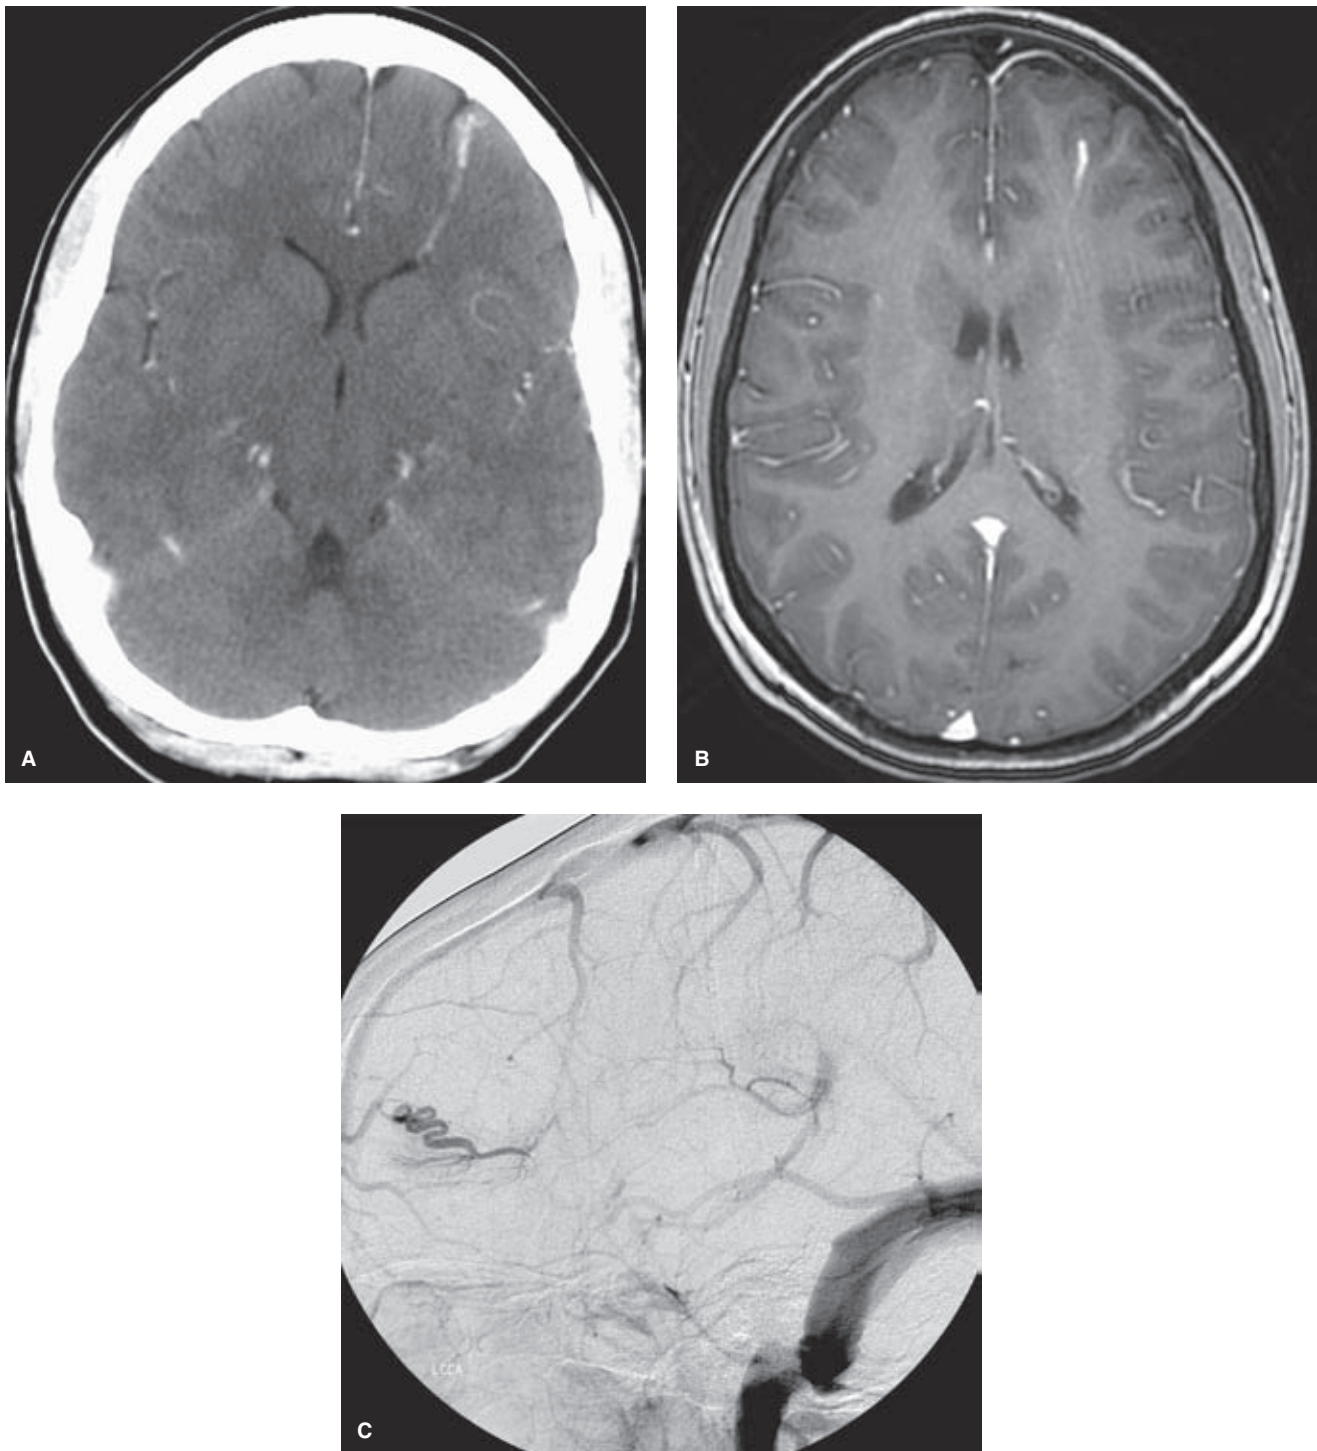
(A–C) Venous anomaly. A teenaged patient presenting with a questionable seizure episode demonstrated a linear enhancing abnormality of the left frontal lobe on contrast-enhanced CT (A). The MRI gadolinium-enhanced study (B) indicated no other evidence of pathology other than that demonstrated on the CT scan, but, nevertheless, an angiogram was requested to exclude the possibility of a micro-AVM. The angiogram of the left common carotid artery (C) shows that the lesion, seen only in the late venous phase, was much more extensive than the noninvasive imaging portrayed. Questions to ask oneself when an indeterminate lesion is being analyzed on angiography: appearance and phase of filling of the supplying vessels; rate of opacification of the lesion; early washout versus late lingering contrast. In this case, the lesion filled late in a posterior to anterior direction. There was no evidence of fistulous flow or of an early draining vein. It is most likely an incidental finding of no relevance to the patient's symptoms.
